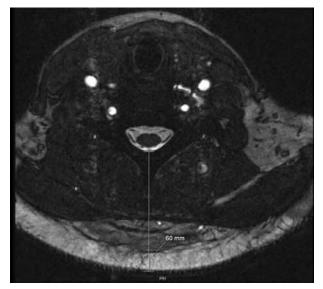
Example of cut of axial MRI image used to obtain depth estimate.
